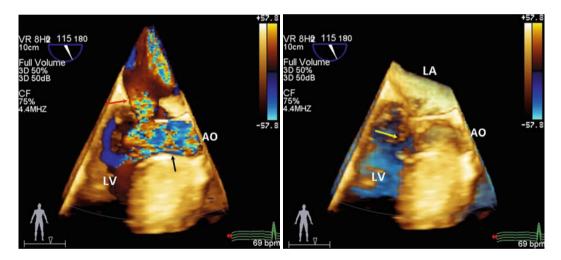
3D TEE color Doppler, long-axis view, showed moderate to severe AR (*arrow*) in diastole
